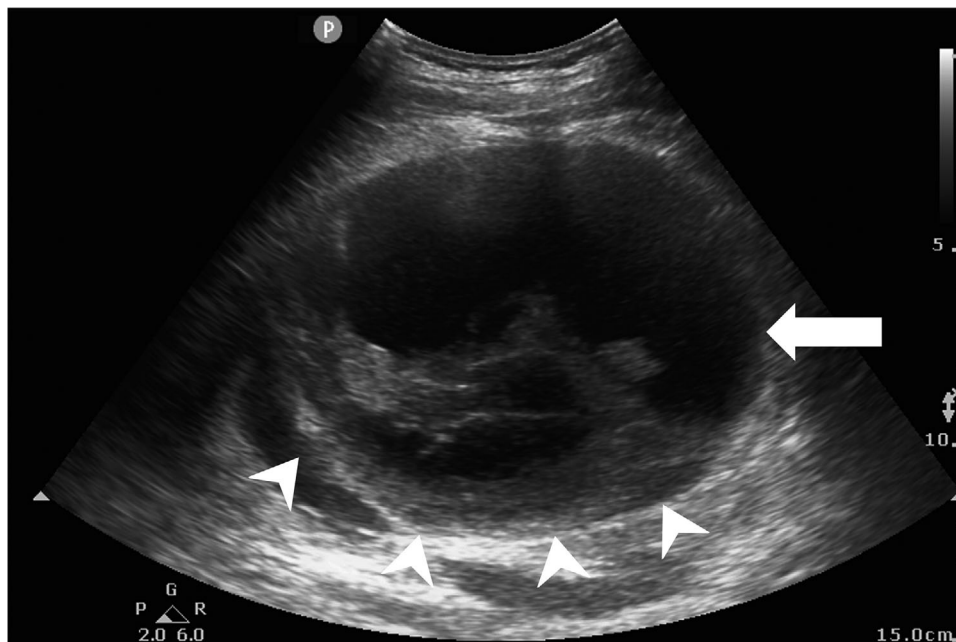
Sonographic image of the left flank region in the horizontal plane showing collapsed left renal parenchyma (arrowheads) compressed by a huge hypoechoic hematoma (arrow).
